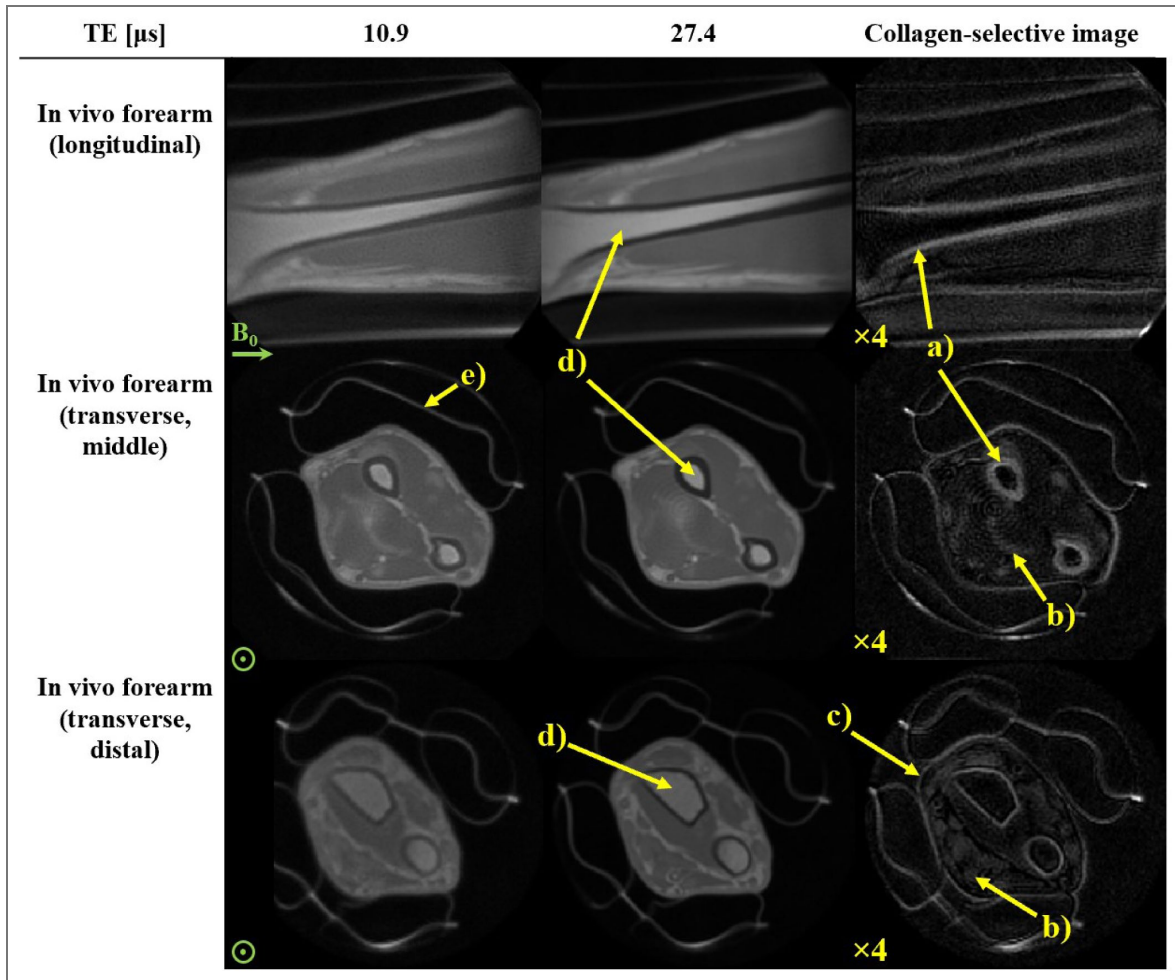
Direct collagen MRI of a right human forearm in vivo.
